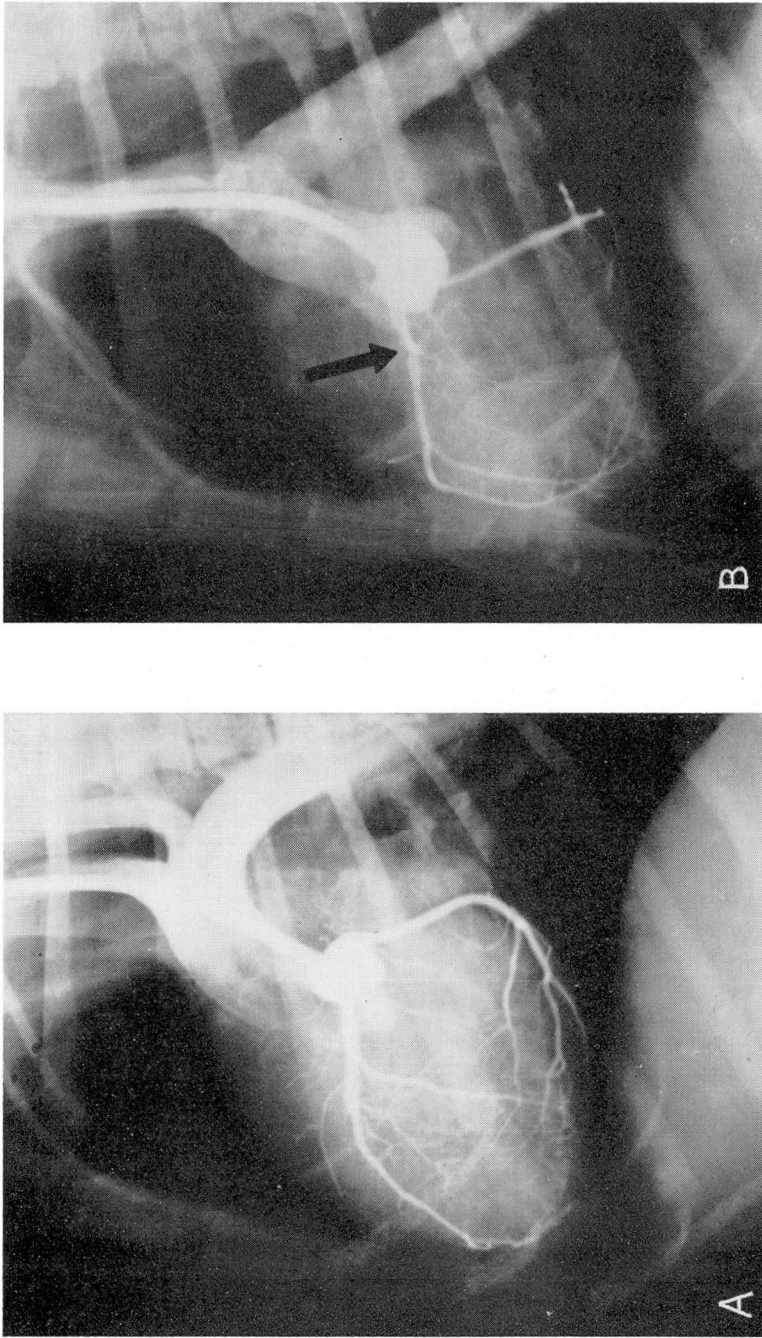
(Narrowing of anterior descending branch of left coronary artery). The tip of the catheter is in the left sinus of Valsalva so that the left coronary artery is filled. A narrow area in the anterior descending branch of the left coronary artery is indicated by the arrow. Above the narrowing, the septal artery is filled. The right coronary artery is not seen in this roentgenogram but was visualized on others.
